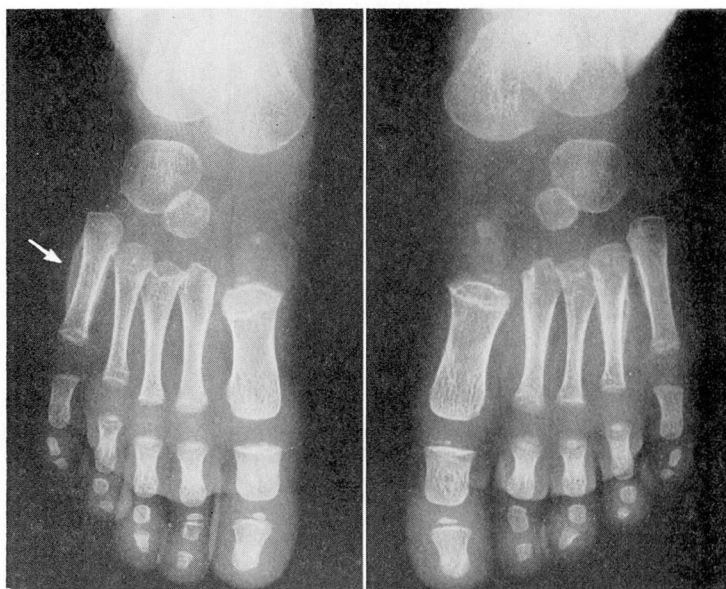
X-rays of feet demonstrate hyperostotic changes on metatarsal bones.
